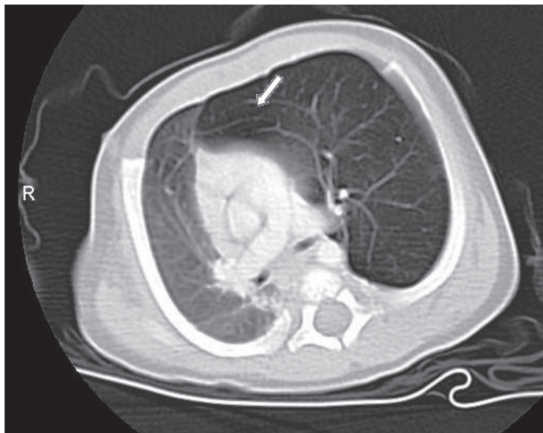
Emphysematous changes were seen on the thorax CT
